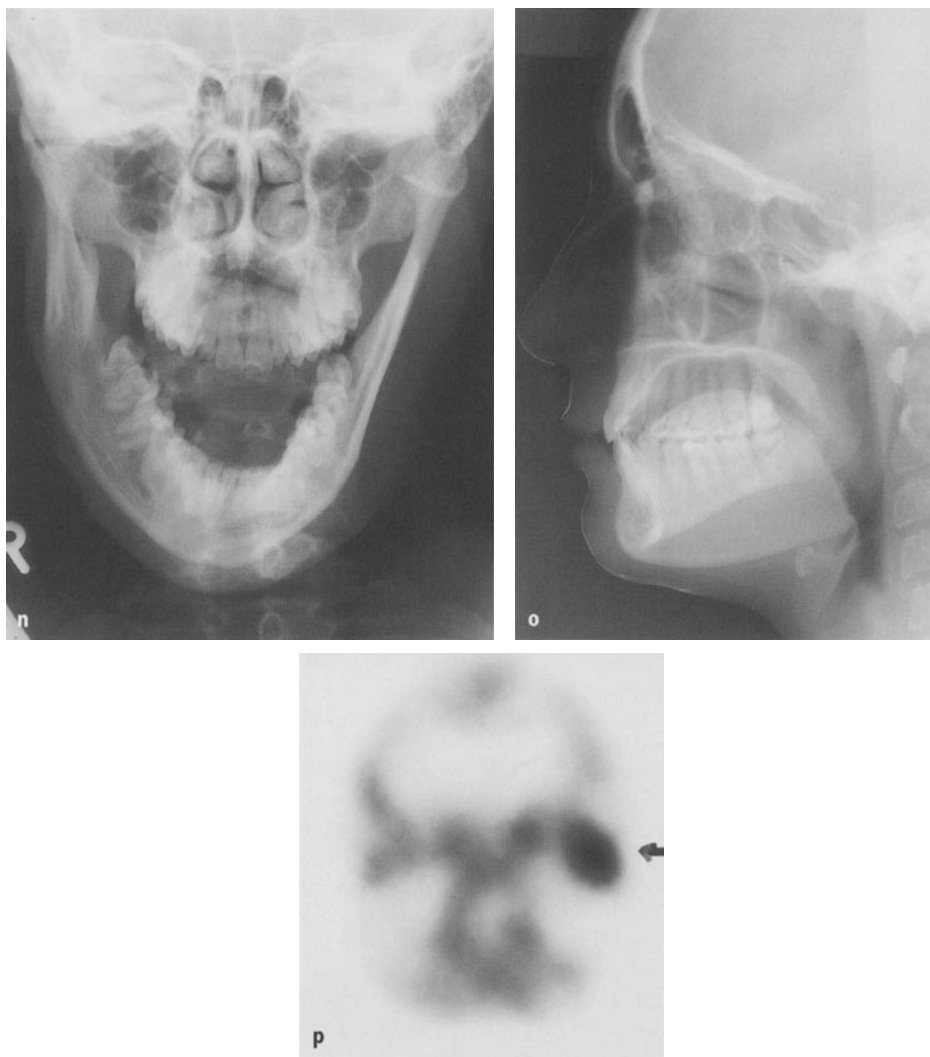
Unilateral hybrid form. n The p.a. projection of the mandible at maximum opening discloses the very severe elongation of the left ascending ramus and the outward rotation of the right hemimandible. o The lateral cephalogram shows best the enormous height difference between the two sides. The profile line is not influenced by this. p The scintigraphic radiograph shows clear hyperactivity of the condyle on the affected side, compared with the normal side
